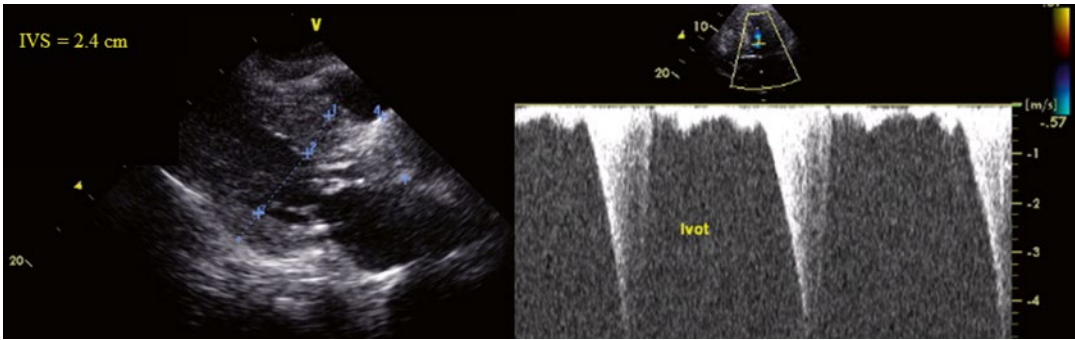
Case 6B. Hypertrophic obstructive cardiomyopathy: 47 year/old male presents for echocardiographic evaluation after a syncopal event and systolic murmur on physical examination Echocardiographic Data (TTE): Moderate to severe concentric LVH noted with septal
